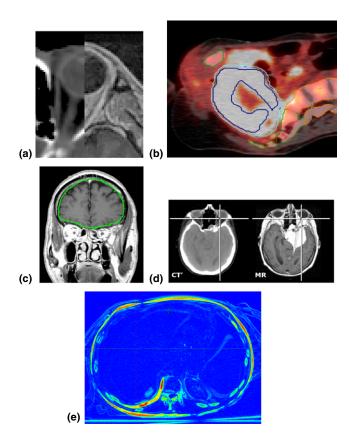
(a) Image—image visual validation using split screen displays of native MR and reformatted CT study. (b) Region of interest delineation overlaid on a fused PET and CT. Contoured are target volumes as identified on PET image and pelvic and vertebral bones as delineated on CT images. (c) Image geometry visual validation structure overlay of CT defined brain outlines over MR images. (d) Side-by-side display with linked cursor. (e) Difference image showing good registration (e.g., solid blue) within the liver, the area of interest, and more uncertainty in the bone and surface (e.g., yellow, green, red color). [Color figure can be viewed at wileyonlinelibrary.com]
